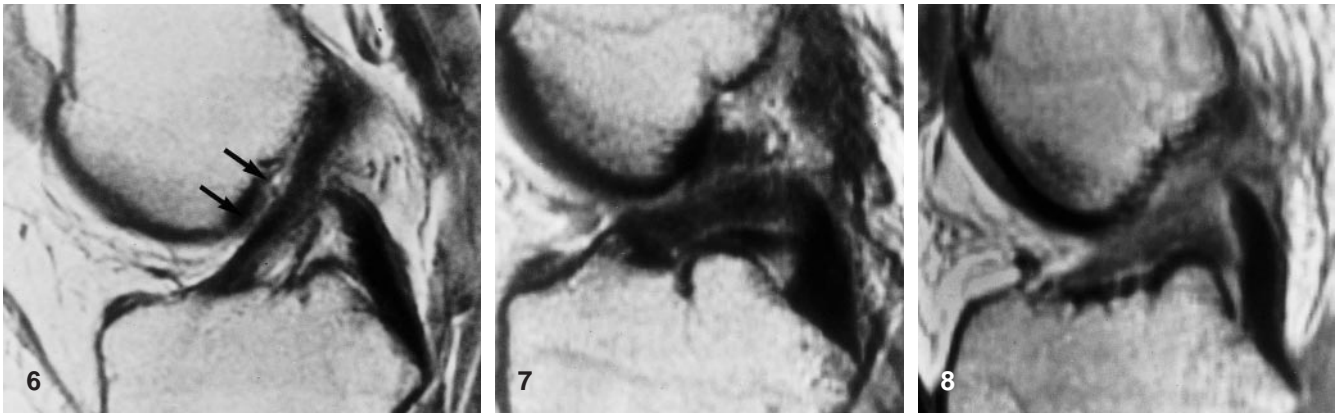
Normal anterior cruciate ligament (ACL). Sagittal proton density MR image (SE 2000/20) showing the ligament extending between the tibial eminence and the lateral wall of the intercondylar notch. The ligament parallels the roof of the notch (*arrows*)
